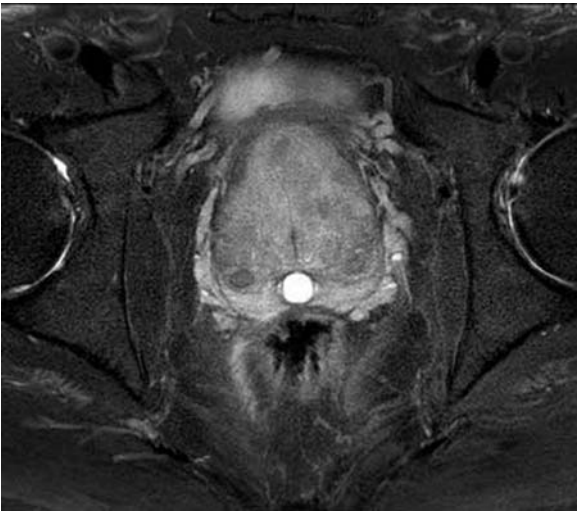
MRI of prostate
